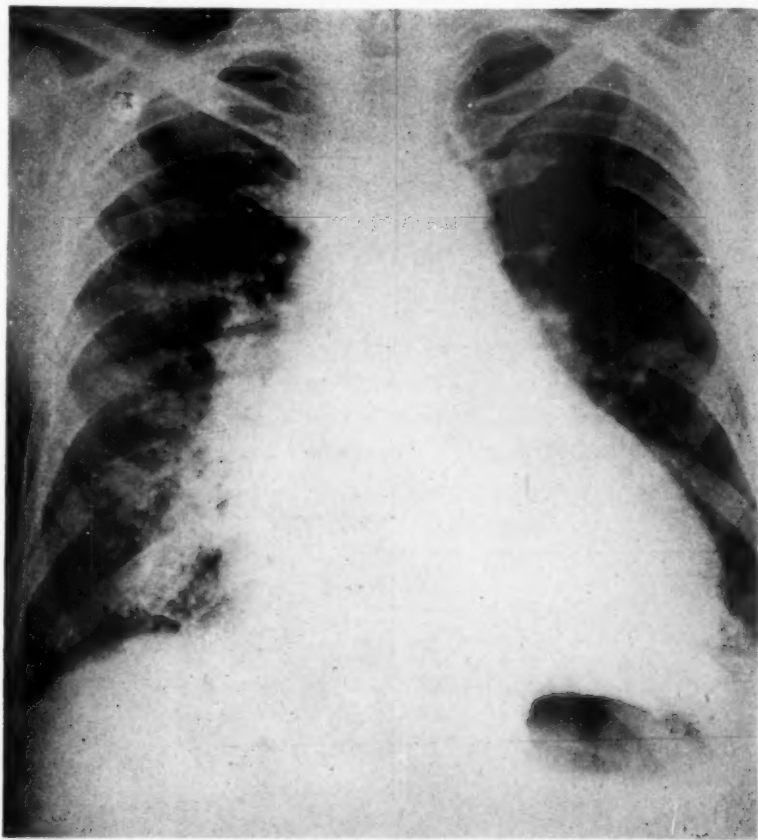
(Case 2).—Roentgenogram of the thorax. Left ventricular enlargement.
